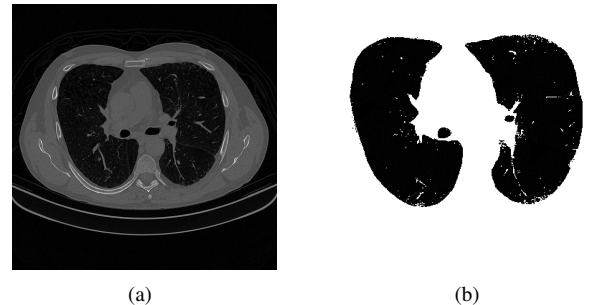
Example of a lung CT scan. (a) The image can be divided into three main parts: lung tissue (the two internal regions, presenting darker color and texture patterns); body cavity (light gray); and the outside (external part). (b) The segmented lung regions.
